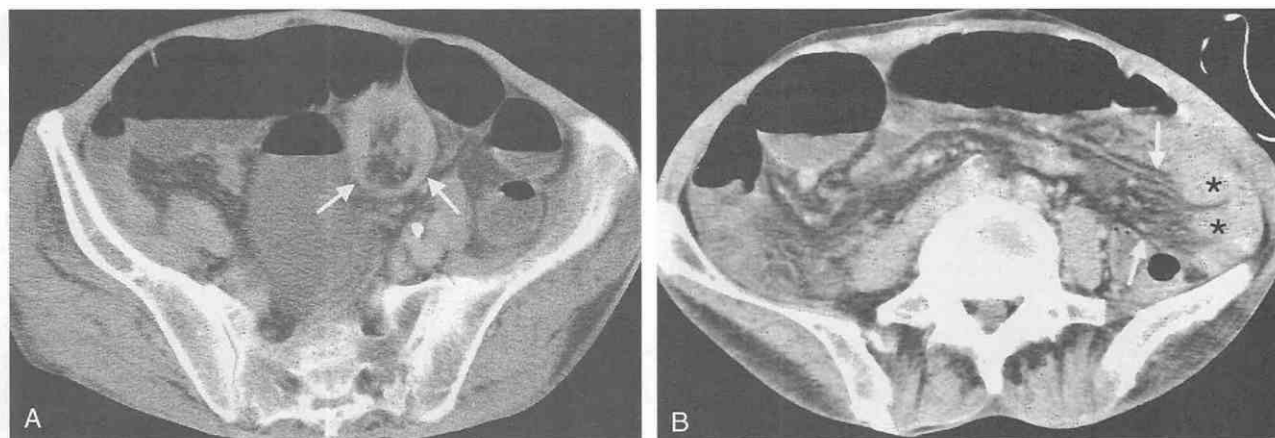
Intussusception with vascular compromise in a patient who underwent gastrectomy 1 year before. *A*, CT scan shows a heterogeneous mass (arrows) caused by invagination of the mesentery. *B*, CT scan at another level shows diffuse haziness and mesenteric vascular prominence (arrows) along with suspected bowel wall thickening (asterisks) in the loops proximal to the obstruction. At surgery, intestinal strangulation was noted in the small-bowel loops proximal to the intussuscepted site. Bowel adhesion was considered to be the primary cause of intussusception.
